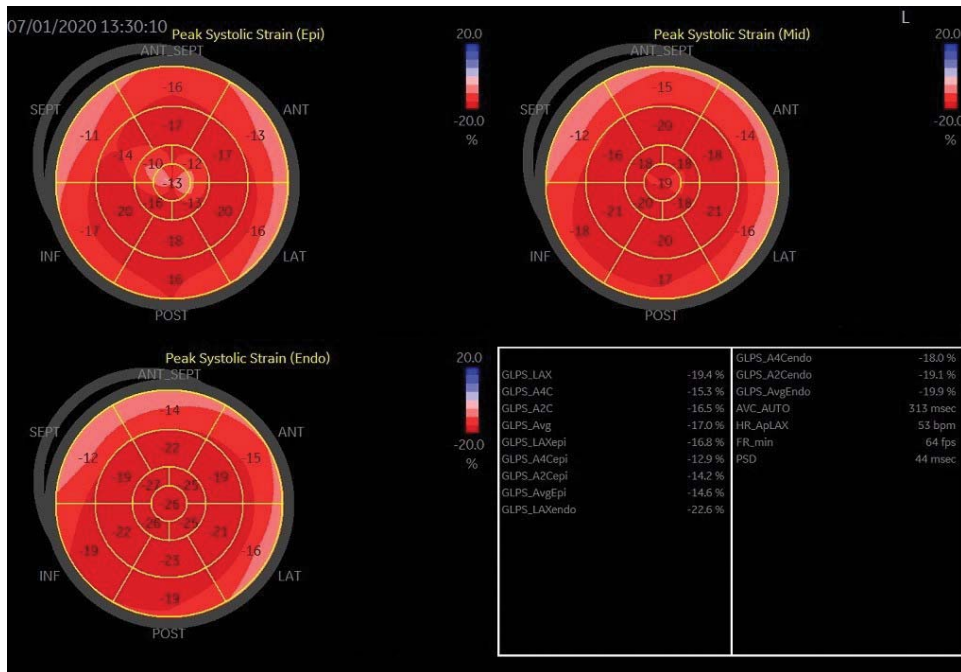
Speckle tracking echocardiography performed 8 days after admission showing decreased global longitudinal strain, especially in the epicardial layer, with a patchy and diffused distribution of reduced strains across all segments.
